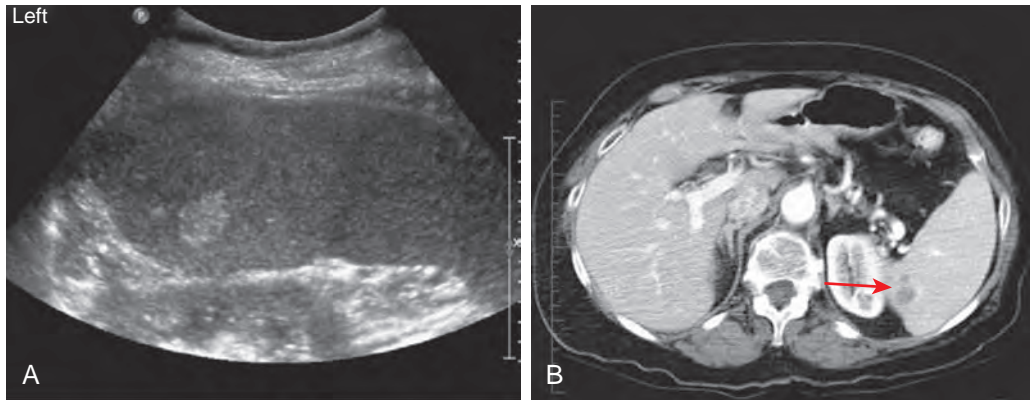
Splenic hemangioma. A. Longitudinal ultrasound image shows a well-defined, hyperechoic lesion. B. Corresponding contrast-enhanced CT demonstrates a hypodense lesion with some faint peripheral enhancement in the portal venous phase (arrow).
